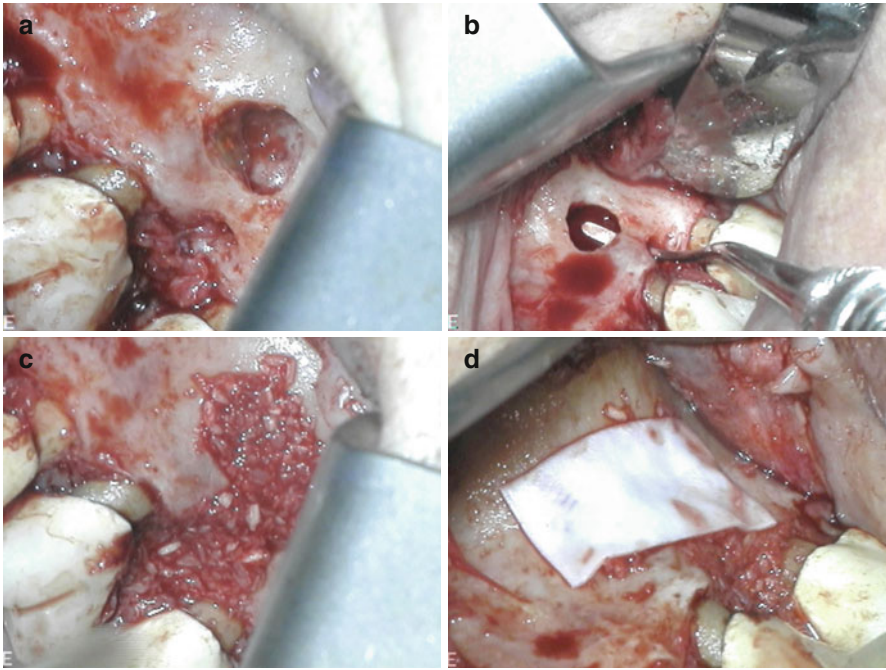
Continuation of case in Fig. 3.12 (a) Clinical picture after flap reflection showing both crestal and periapical lesions. (b) Communication between both defects. (c) Both defects grafted with an EnCore™ combination allograft (Osteogenics Biomedical, Lubbock, TX). (d) CopiOs pericardium membrane (Zimmer, Warsaw, IN)
